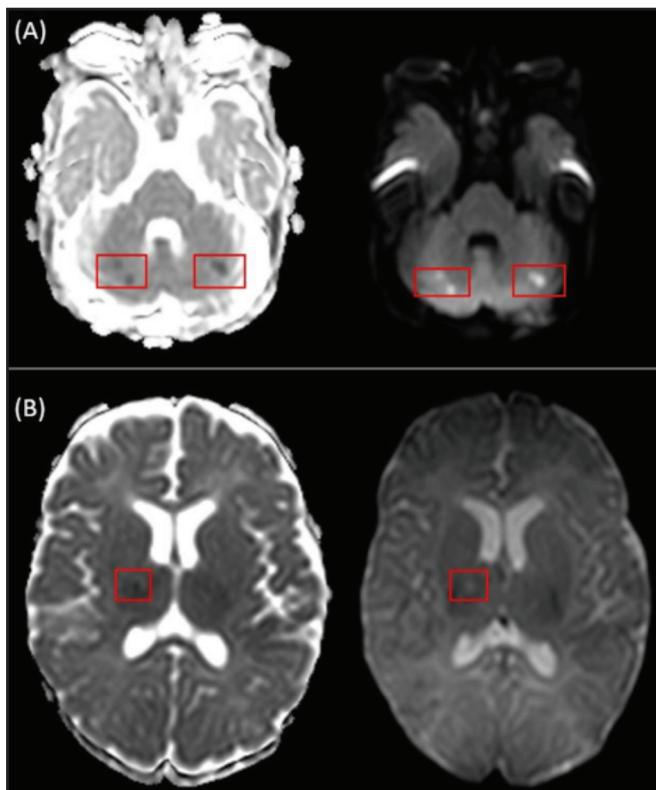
MRI brain (Apparent diffusion coefficient/Diffusion weighted imaging sequence) showing restricted diffusion (red box) over bilateral cerebellar white matter (A) and right thalamus (B).
